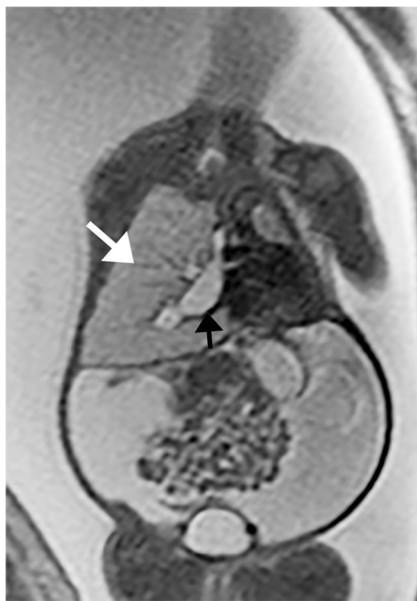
Bronchial atresia. Coronal single-shot turbo spin-echo (SSTSE) MR image demonstrates a central bronchial atresia in a 26-week fetus manifested by obstruction and dilatation of the bronchi centrally (*black arrow*) and retained, hyperintense fluid distally (*white arrow*). The contralateral lung is markedly hypoplastic. The fetus is starting to demonstrate stress manifested by the large amount of ascites. There is no frank hydrops
